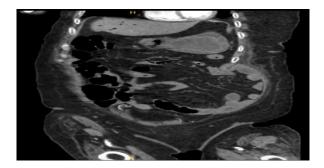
CT abdomen coronal view.
